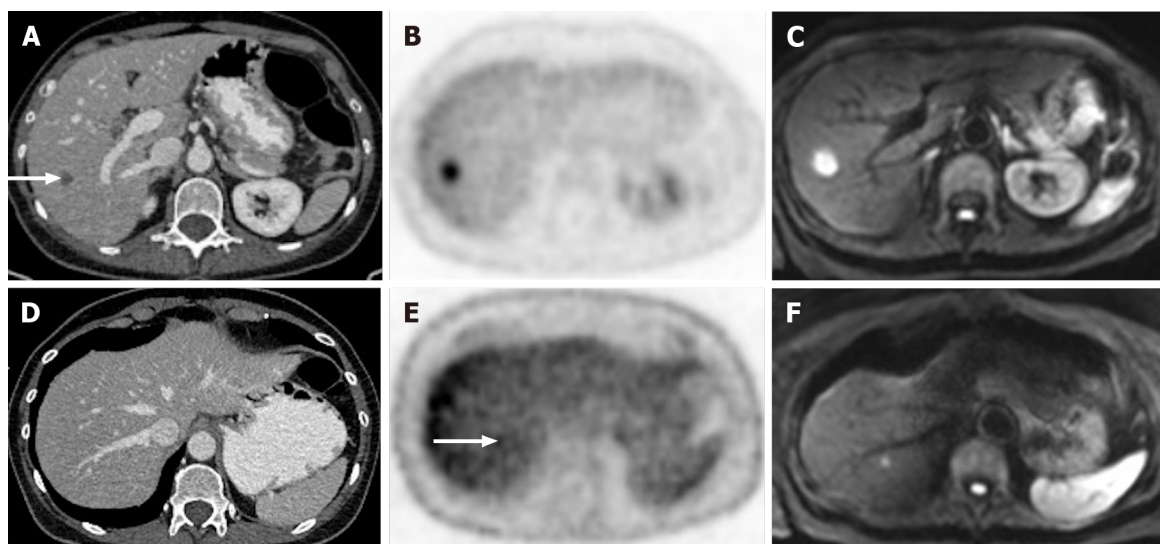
A 65-year-old woman with colorectal carcinoma shows liver metastasis in segment VII. A: Axial contrast-enhanced computed tomography (CE-CT) reveals a hypodense lesion corresponding to liver metastasis (arrow); B: Fluorodeoxyglucose (FDG) positron emission tomography (PET)-CT confirms metastatic origin; D: Axial CE-CT shows no apparent lesion; E: FDG PET-CT shows an additional barely visible nodule not seen in CT (arrow); C and F: Diffusion-weighted imaging confirmed that both lesions were secondary.
